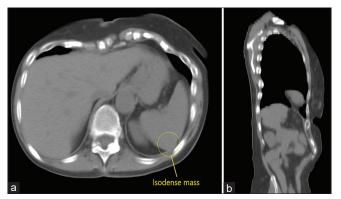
Isodense splenic mass visualized on computed tomography scan. Axial view (a), sagittal view (b)
